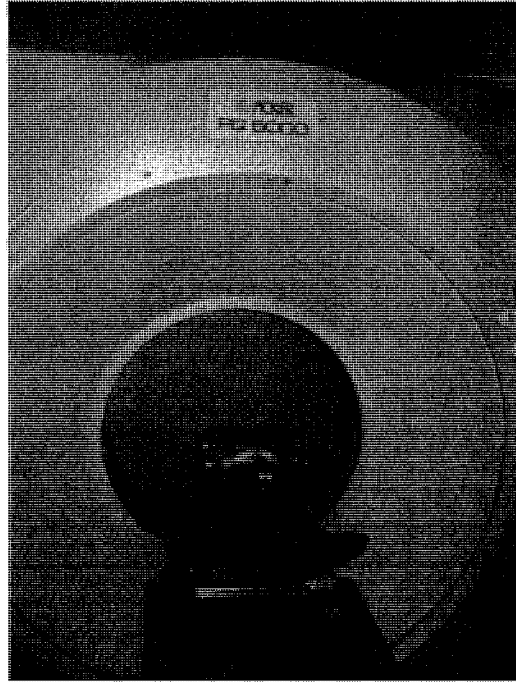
The Picker PQ-5000 CT scanner was used for the collection of diagnostic images for the six test case studies.
